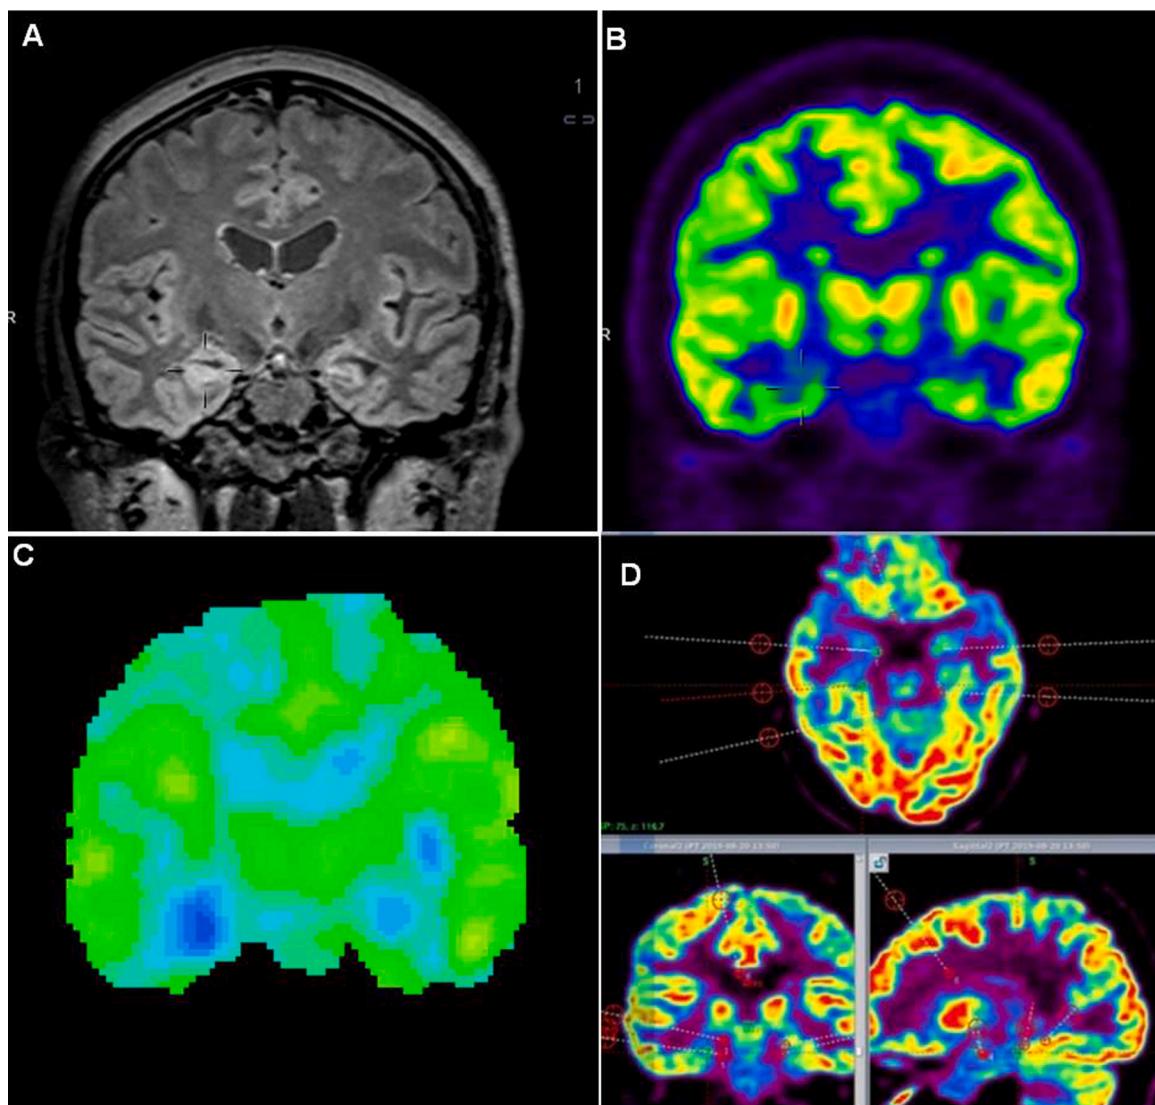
Hybrid PET/MRI navigate SEEG electrodes implanting.
